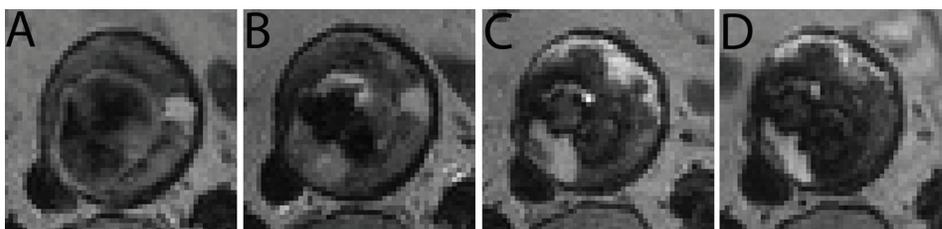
T2-weighted images before EVAR (A), postoperative (B), 6 months (C) and 1 year (D) after EVAR. The unorganized thrombus volume (high signal intensity) decreases in time. This patient had a shrinking aneurysm without evidence of endoleak.
